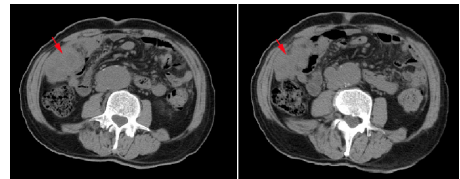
A 67-year-old man was found abnormal peripheral blood leukocyte count in the Lab test, which fluctuated between 37720/ μ L and 78570/ μ L. Abdominal Pelvic CT showed peritoneum multiple occupying lesions in the parietal peritoneum, the largest of which was 6.0cm \times 4.0 cm (Red arrow). His physical examination was unimpressive and there are no significant findings in the Gastroscopy and Colonoscopy, and 18F-FDG PET/CT was performed for further evaluation.
